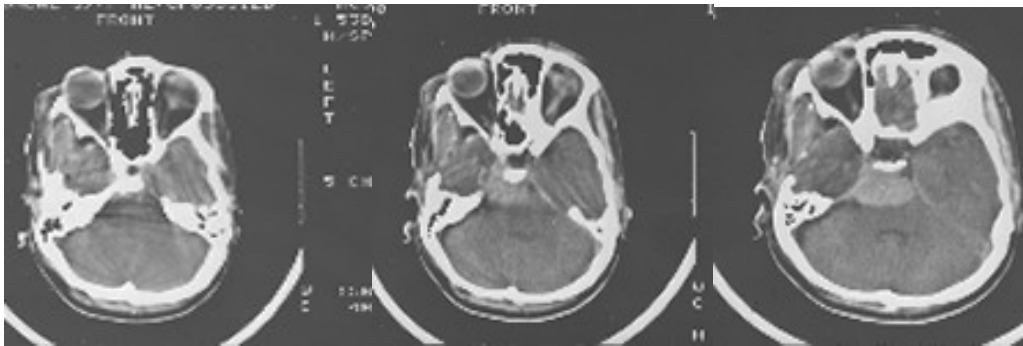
showing immediate postoperative axial contrast CT scans in a 37 year old female who presented with headache, and cranial nerve involvement 5, 7, 8. She had undergone a frontotemporal approach and partial excision of a petroclival meningioma.
